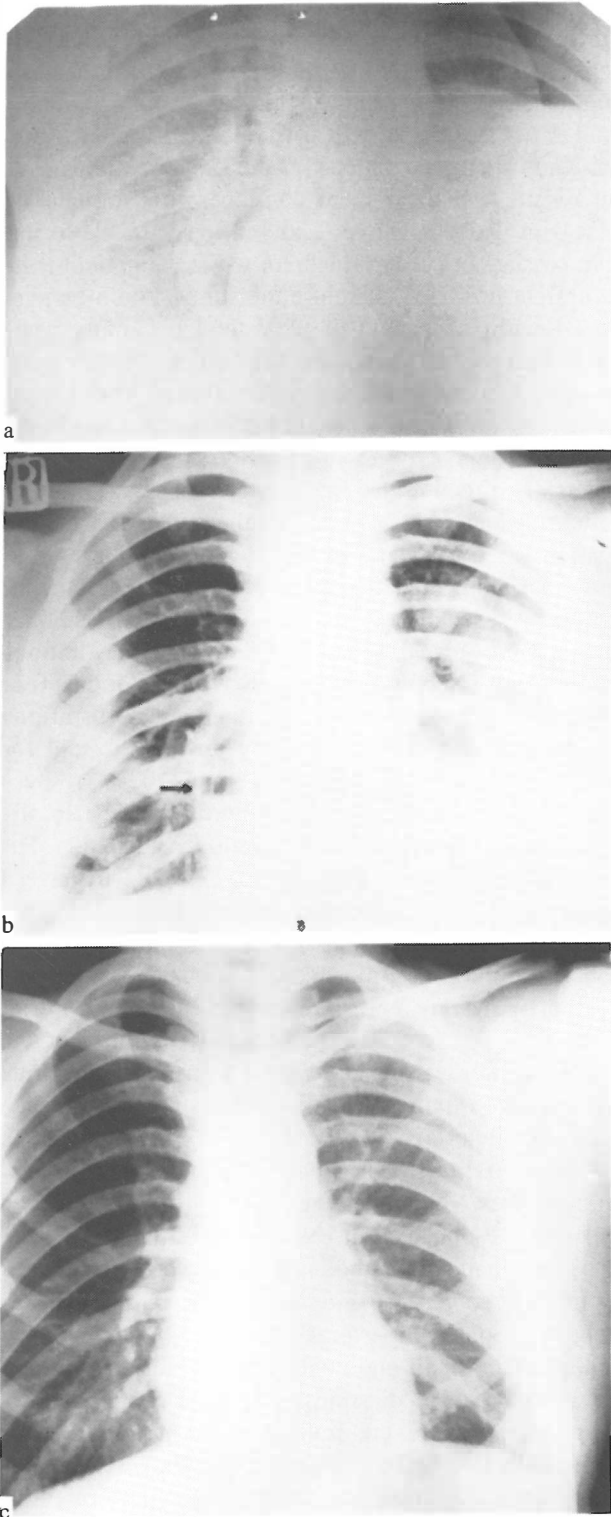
Pyothorax and purulent pericarditis secondary to esophageal perforation. Admission chest radiograph shows large hydropneumothorax on the left (a). Erect chest x-ray of the same patient after drainage of the left and right pleural cavity. Note air-fluid level in the pericardial sac (purulent pericarditis) (b). Chest x-ray of the same patient 1 year after discharge from the hospital (c).
